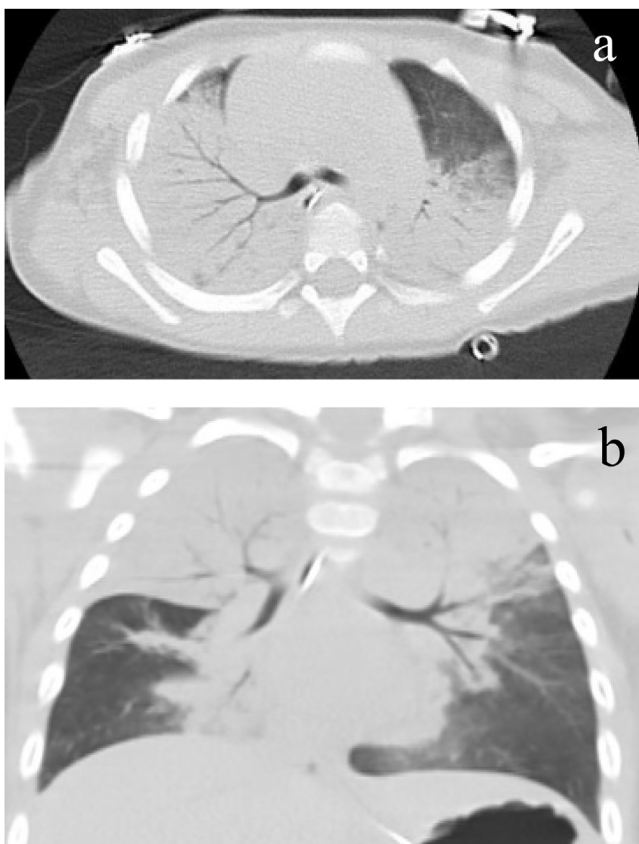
CT findings of case 2. Horizontal (a) and coronal (b) sections obtained during chest computed tomography in case 2, showing confluent alveolar consolidations, predominantly in the dorsal regions.
